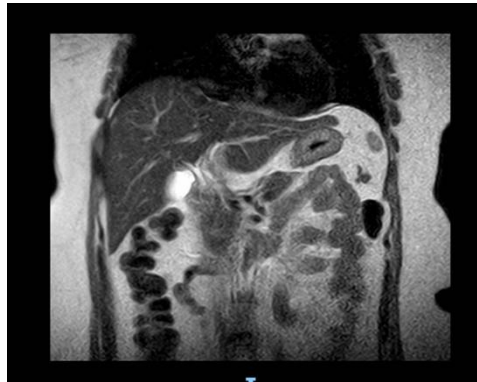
Abdominal MRI with contrast
